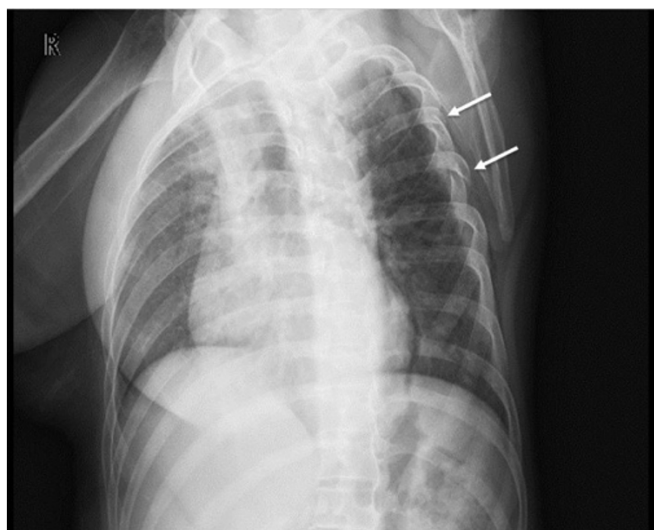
Chest x-ray depicting multiple rib fractures of the left fourth and fifth ribs (arrows).
